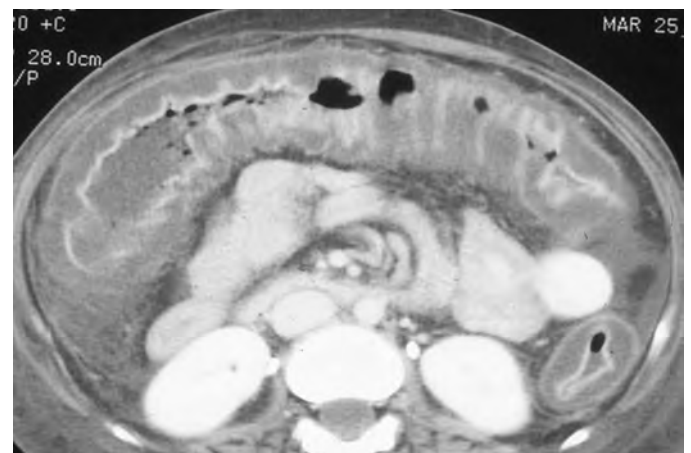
Cytomegalovirus (CMV) colitis. CT scan demonstrates severe mural thickening of the transverse colon in this patient with AIDS. Note the edematous low-density submucosa, with enhancement of the mucosa and serosa.
